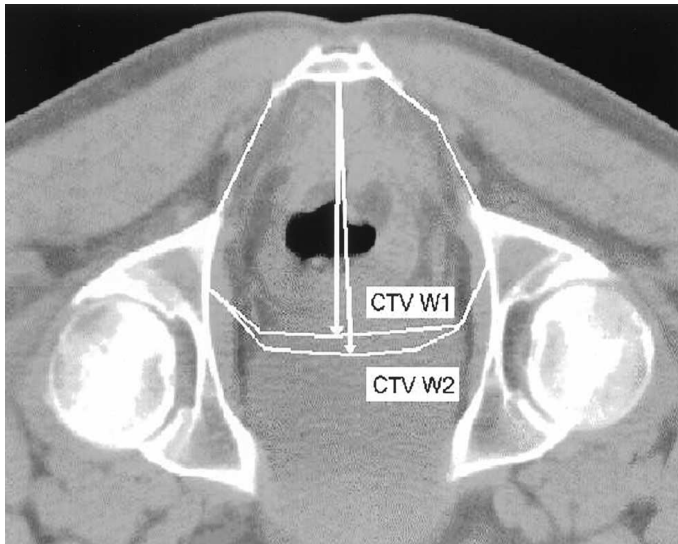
Measurement of the anterior border of the CTV. CTV W1 = clinical target volume of the first CT scan taken during the first week of treatment. CTV W2 = clinical target volume of the second CT scan taken during the second week of treatment.
